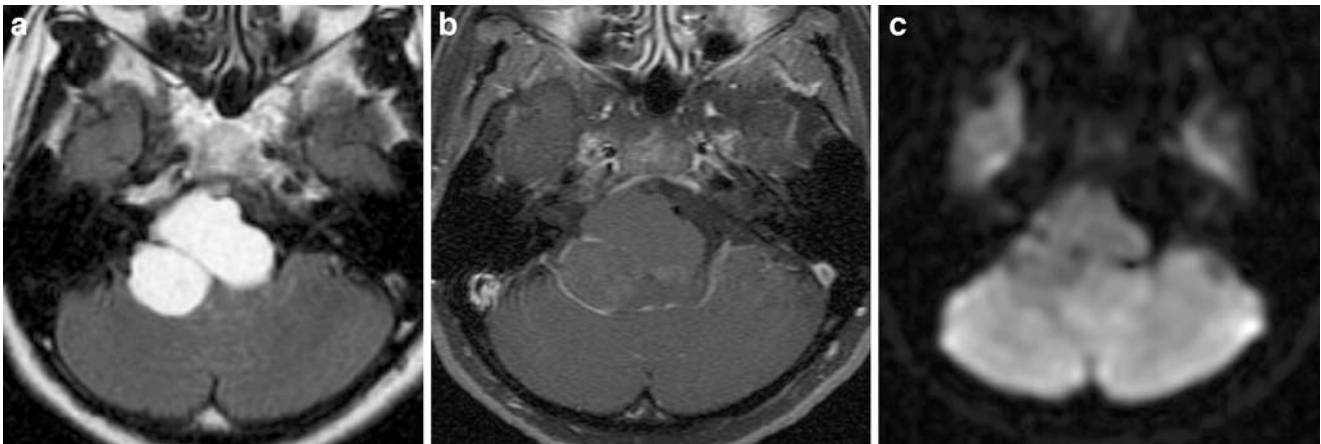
Neurenteric cyst in 46-year-old man with cranial nerve palsies. a Axial FLAIR image reveals a cystic mass in the right CPA with smooth margins and an unusual homogeneous marked hyperintense signal. b Axial contrast-enhanced T1-weighted image with fat suppression only demonstrates a subtle peripheral linear
